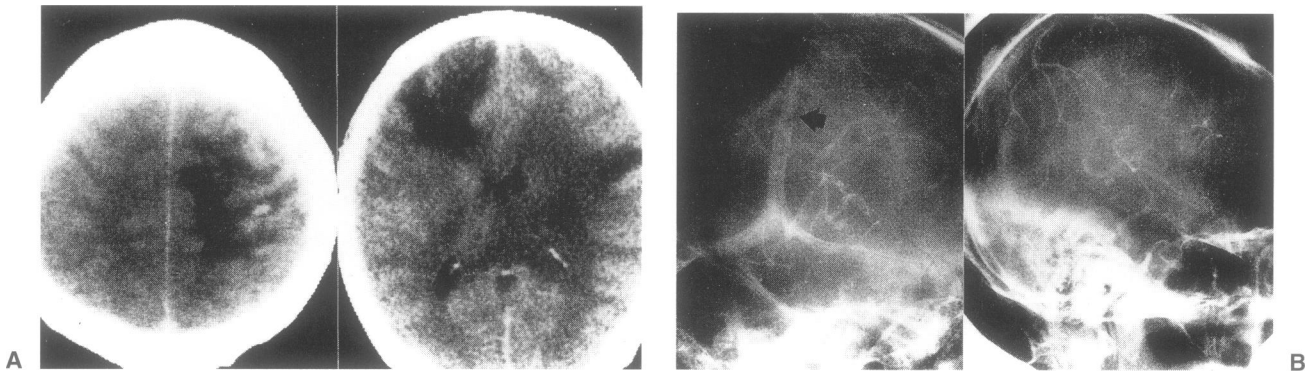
(A) Emergent CT revealed low density areas in the right frontocentral and left frontal regions. (B) Angiography revealed the occlusion of middle 1/3 in SSS.
